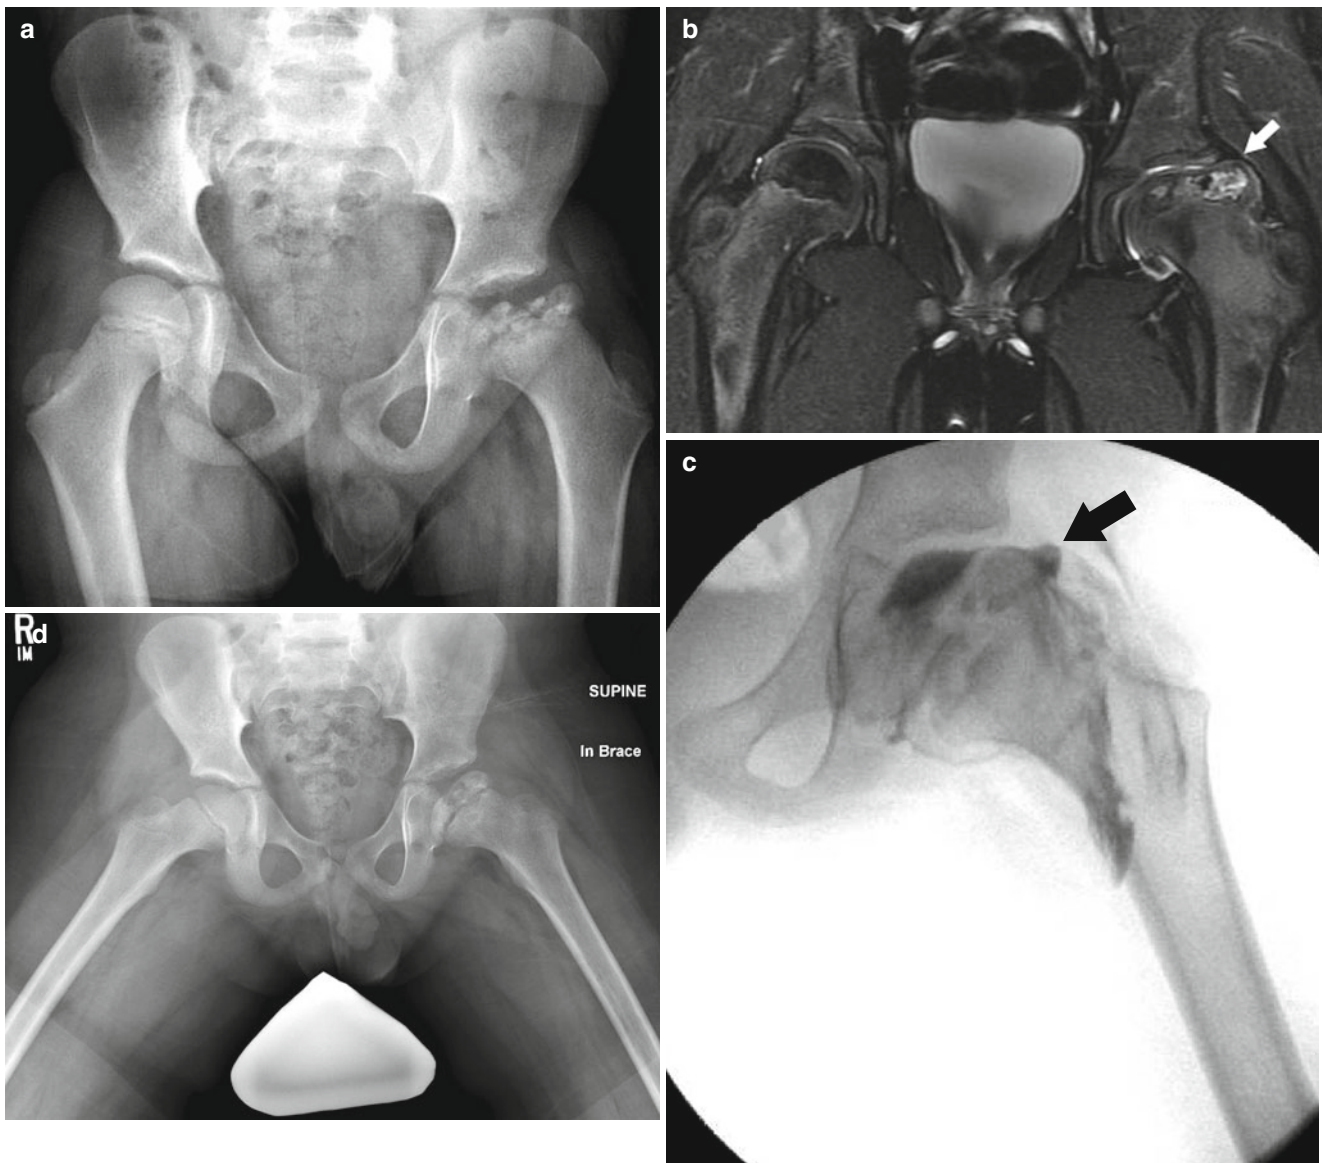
A 7-year-old male complaining of left groin pain and limping for 1 year. This patient was treated in another institution with physiotherapy but no restriction of activities. When the patient presented for a second opinion, he had a very stiff hip with less than 10° of abduction with hips extended. (a) AP radiograph showing fragmented and deformed epiphysis on the left side with lateral extrusion. (b) MR T2 image showing a depression into the lateral epiphysis by the edge of the acetabulum and the extruded epiphyseal segment impinging of the labrum (*arrow*). (c) Hip arthrogram following a
